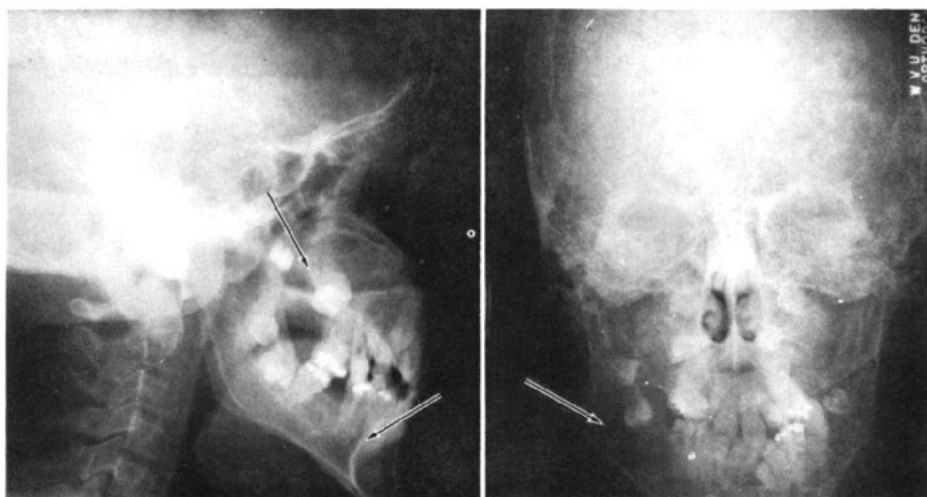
Lateral and frontal x-ray showing extensive cystic areas involving angle of mandible, symphyseal area and the maxilla. Note that the teeth are displaced.
